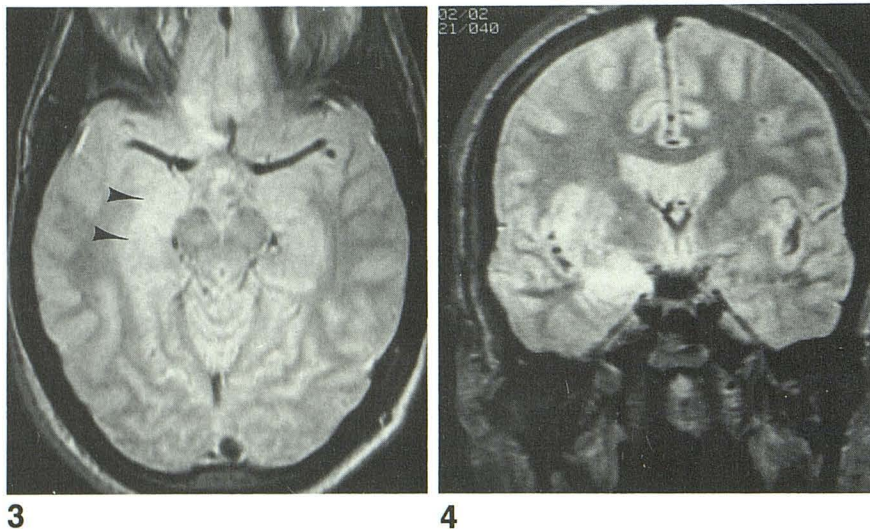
Case 15: 25-year-old man with 9-year history of complex partial seizures. Temporal lobe resection revealed severe mesial temporal sclerosis. T2-weighted axial image (2500/80) shows subtle but definite increase in signal intensity in medial third of temporal lobe (arrowheads). Increased signal was rated as 1+.
